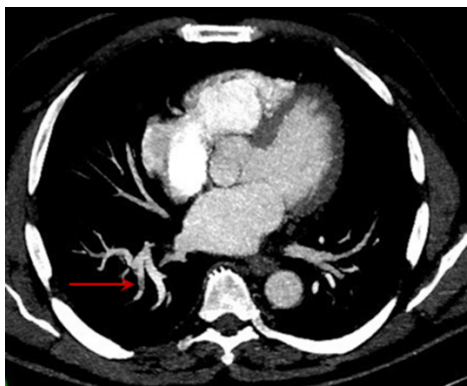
Chest CT scan, mediastinal window taken at the level of the inferior pulmonary lobes (arrow showing right lower pulmonary embolism).
